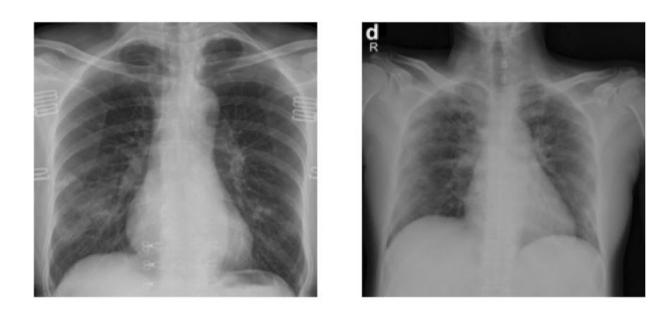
X-ray samples of Covid19 Positive Images
